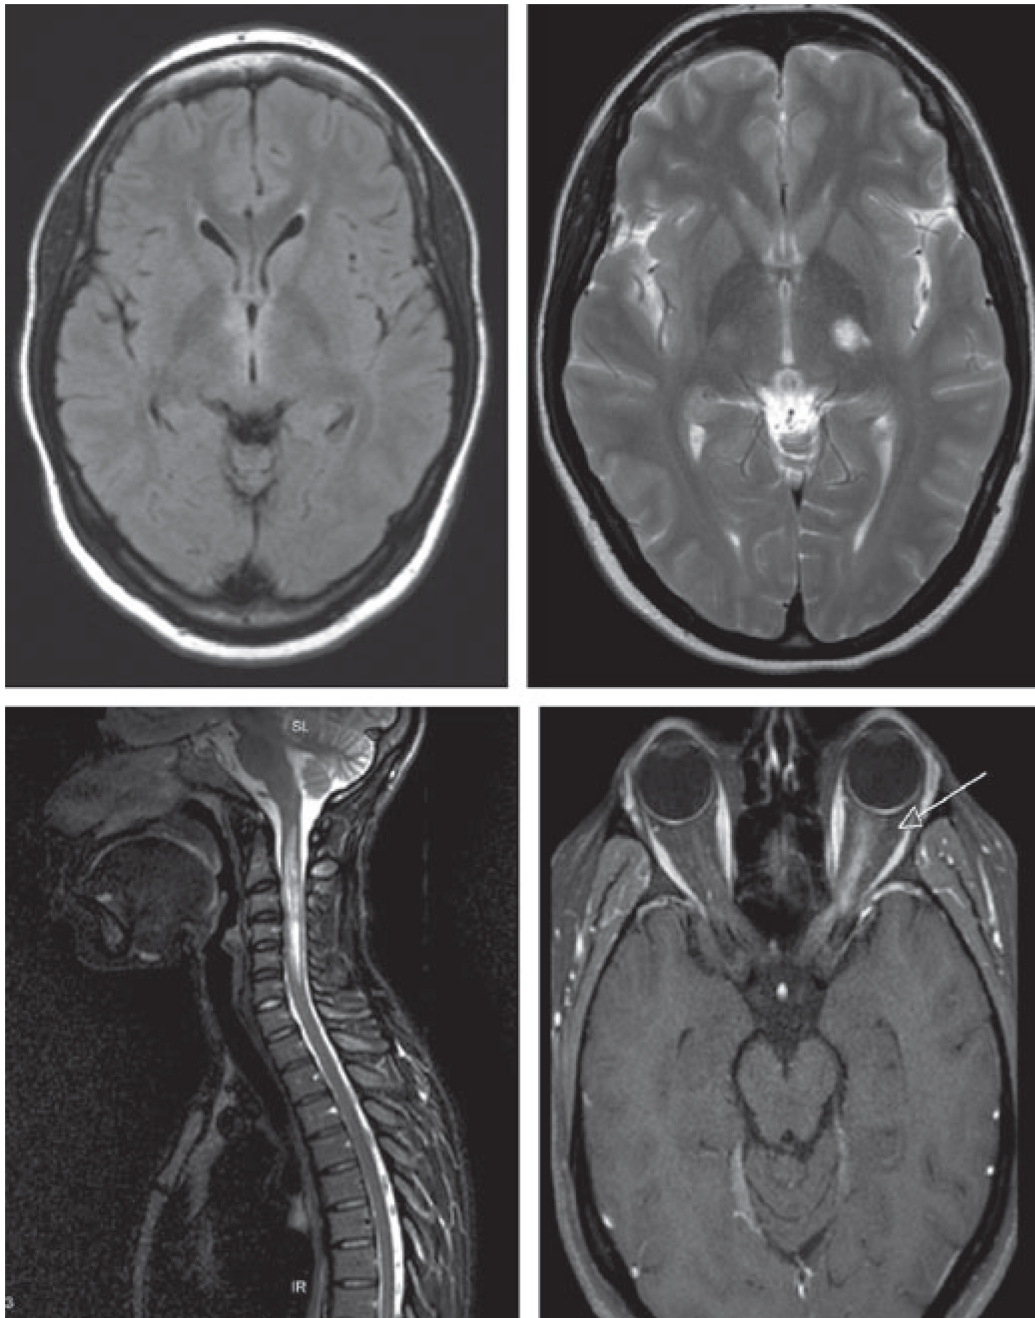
Central nervous system lesions typical of neuromyelitis optica (NMO). Representative magnetic resonance imaging (MRI) of patients with NMO seropositive for anti-aquaporin4 antibodies/ NMO-IgG, from the authors' clinic. (A) Fluid-attenuated inversion recovery (FLAIR) shows signal abnormality around the third ventricle. (B) T2-weighted MRI signal abnormality in the thalamus and posterior limb of internal capsule on the left side. (C) Sagittal T2-weighted MRI of cervical spinal cord from a patient with NMO, showing longitudinally extensive transverse myelitis with swelling. (D) Gadolinium enhancement T1-weighted image shows optic neuritis on the left side. Figure and legend (Asgari et al., 2011). Copyright 2010 with permission John Wiley & Sons A/S
